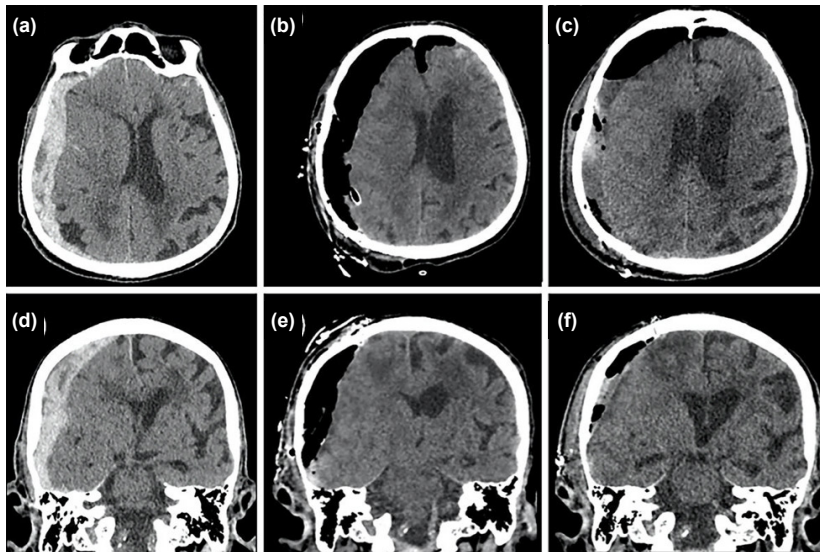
Axial (a) and coronal (d) CT scans of an 87-year-old man not on anticoagulant therapy, who developed confusion following a traffic accident, reveal a right frontoparietal SDH. Preoperative neurological examination indicated a GCS score of 9. The patient underwent an urgent surgery, and the SDH was evacuated via open craniotomy. Early postoperative axial (b) and coronal (e) CT scans demonstrate regression of the midline shift caused by the hematoma and pneumocephalus. Axial (c) and coronal (f) CT scans performed one week after the traumatic event show the resolution of the pneumocephalus, and no reoperation or additional intervention was required as there was no evidence of a compression effect.
